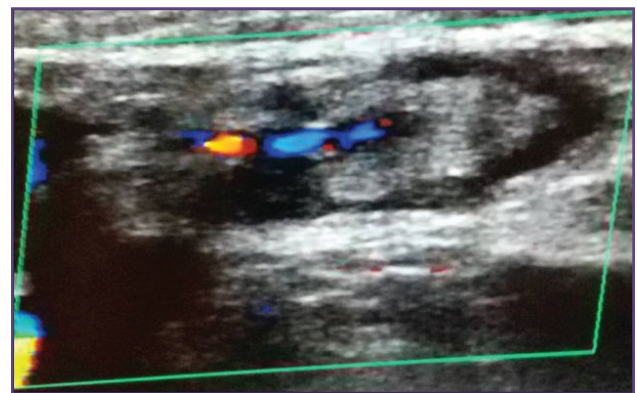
Colour doppler image showing a large lymph node measuring 3x1.5 cm with echogenic centre and cluster of color signals in the hilum of the node.
